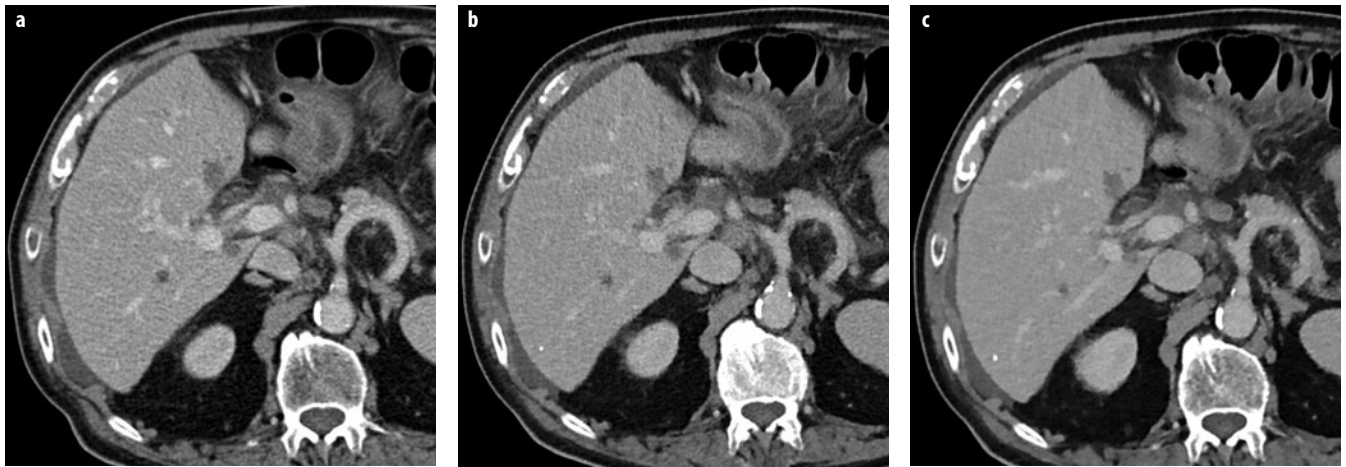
a-c. Dose reduction using iterative reconstruction techniques at multidetector computed tomography (MDCT). a Normal-dose MDCT in the venous phase (120 kVp, ref. mAs 230) reconstructed with standard filtered backprojection shows colorectal liver metastases. b Image appearance (120 kVp, ref. mAs 150) using iterative reconstruction (SAFIRE level 3) is slightly different in general due to reduced image noise. Lesions are shown with the same conspicuity. Patient dose is reduced by 36%. c At higher iterative reconstruction levels (SAFIRE level 5), the image appearance is pixilated (plastic-like), especially the liver parenchyma and perirenal fat
